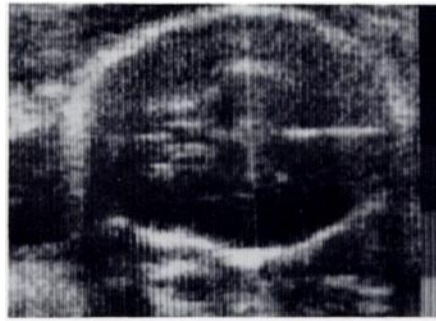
Case 1. Real-time sonographic image shows dolichocephalic shaped fetal skull in 35 week fetus. BPD (7.9 cm) suggested gestational age of 32 weeks, while head circumference (32 cm) was appropriate for 35 weeks.
